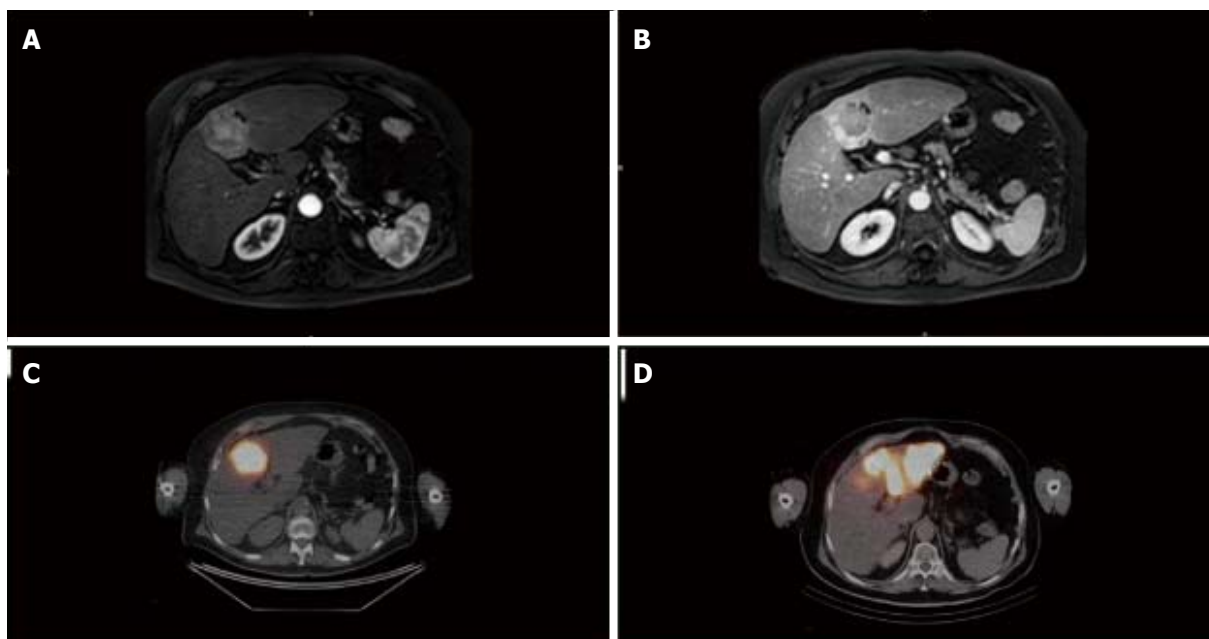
Preoperative imaging. A and B: Baseline contrast-enhanced magnetic resonance imaging (MRI). Contrast-enhanced MRI demonstrated a 40 mm mass in segment IV of the liver with arterial wash-in (A) and wash-out on the portal venous phase (B) and features of cirrhosis (irregular surface, relative hypertrophy of segment I); C and D: Selective intra-tumor deposition of ^{90}Y microspheres after first SIRT session (C) and deposition of ^{90}Y microspheres to segments II and III after the second SIRT session (D).
